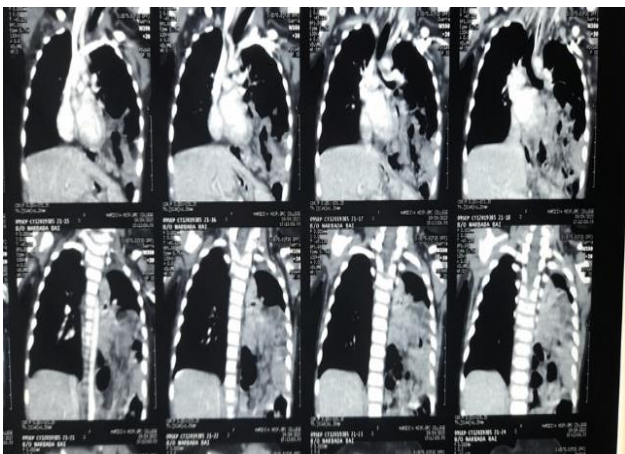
CT of chest and abdomen showing left-sided CDH (case 5).
